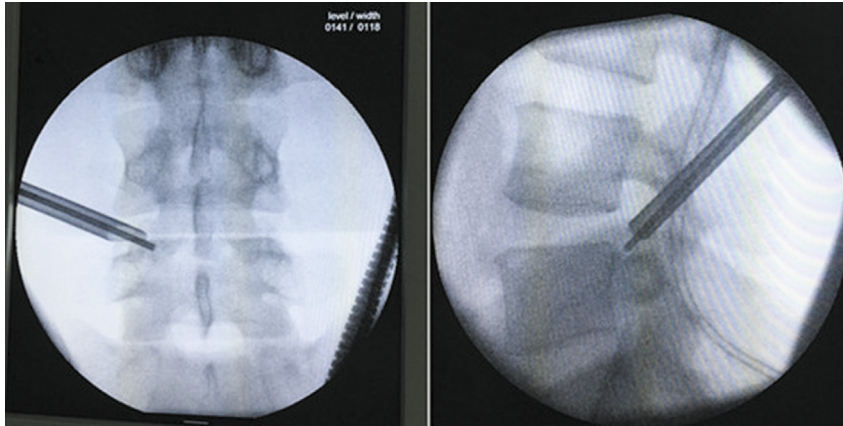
The spinal needle reached the target point on the anteroposterior and lateral radiography.
